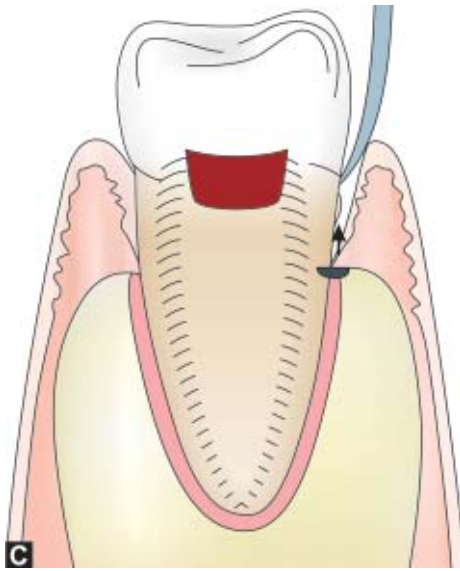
Removal of concretions and tartar using ultrasonic scalers and special hand instruments
